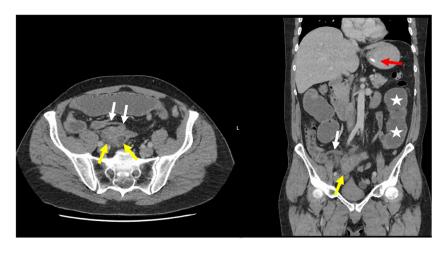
Axial and coronal views of a repeat CT scan demonstrating a collection in the right iliac fossa (yellow arrows), with a normal appearing appendix which appeared to communicate with the collection (white arrows). The small bowel is dilated (white star) and a nasogastric tube is seen in the stomach (red arrow).
